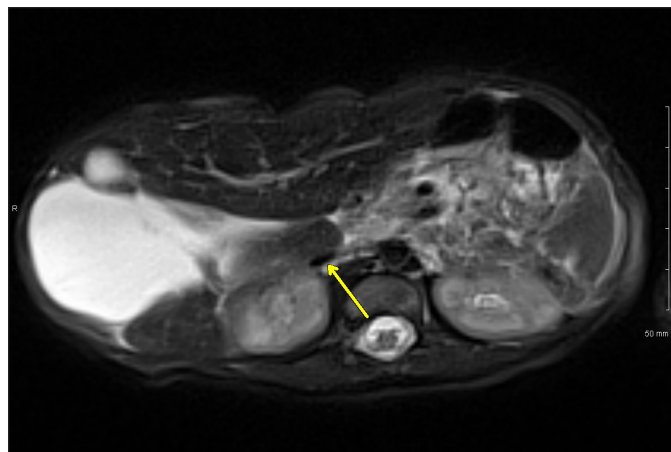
Postnatal MRI axial T2 image demonstrating a compressed IVC (arrow) and liver parenchyma anterior, posterior, and medial to the cyst.
